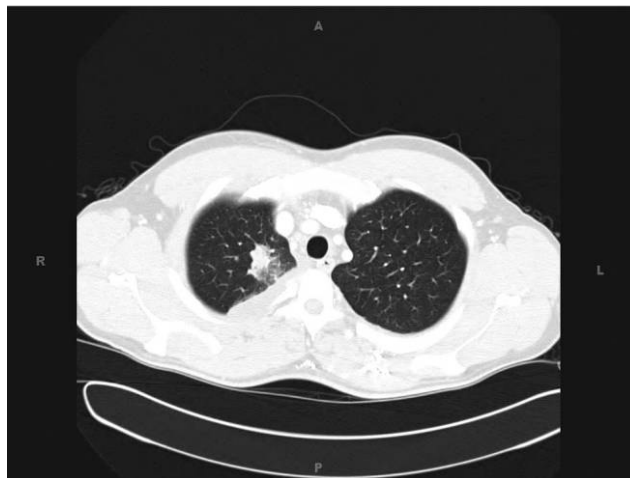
Computed tomography scan of the chest of patient 3 showing a right apical mass.
